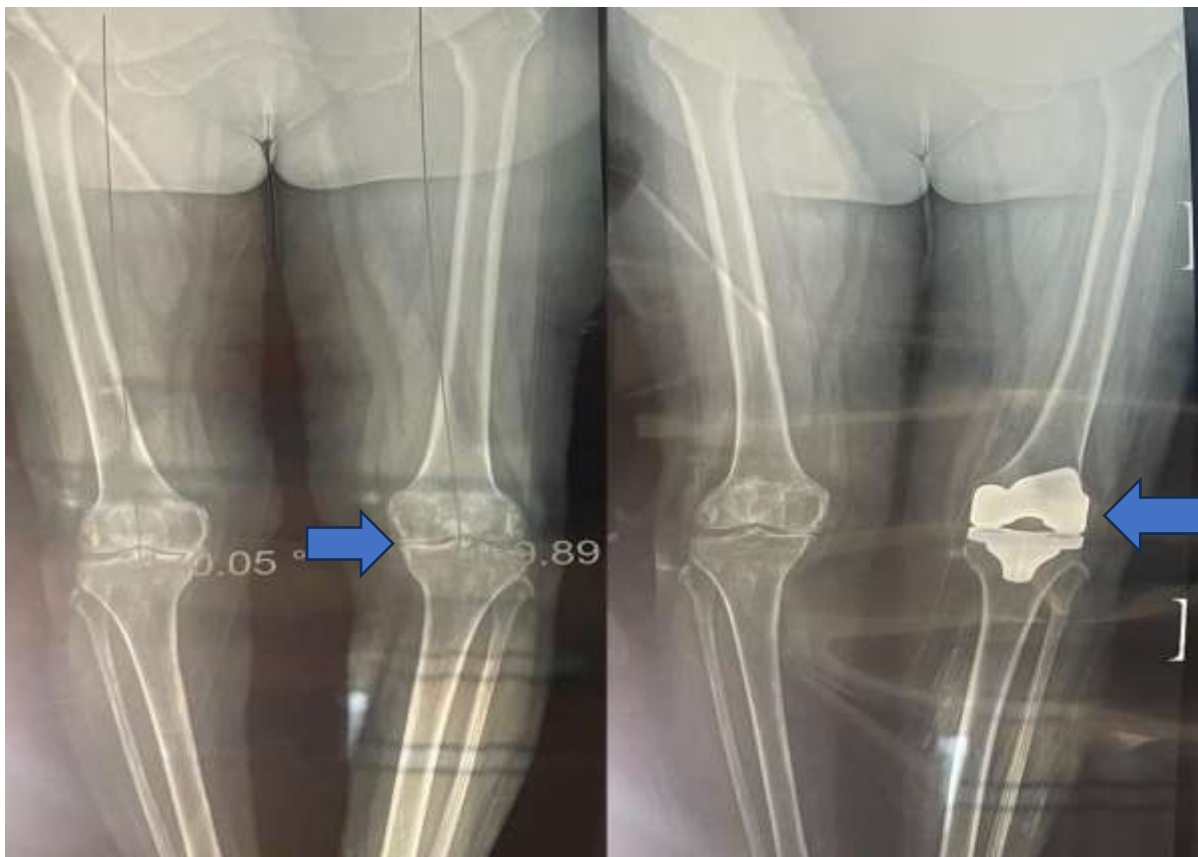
Pre and Post X-ray
